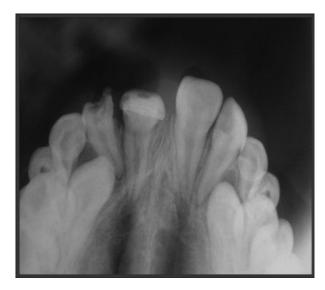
Occlual radiograph.
